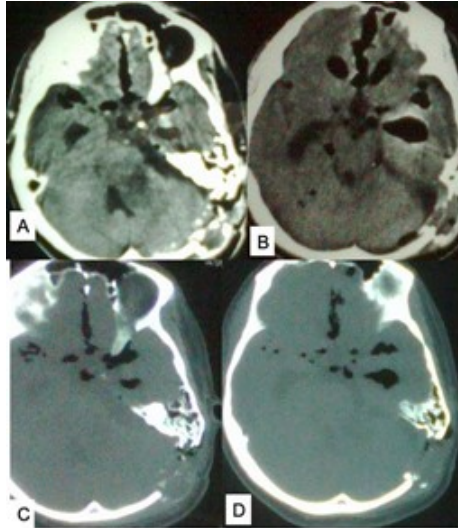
CT scan of head. (A,B) Axial images and (C,D) axial images in bony window showing extensive pneumocephalus after retro-sigmoid craniectomy for acoustic schwannoma where CSF rhinorrhea and otorrhea were developed through mastoid air sinus, middle ear cavity, and eustachian tube. Source: Figure by authors.
